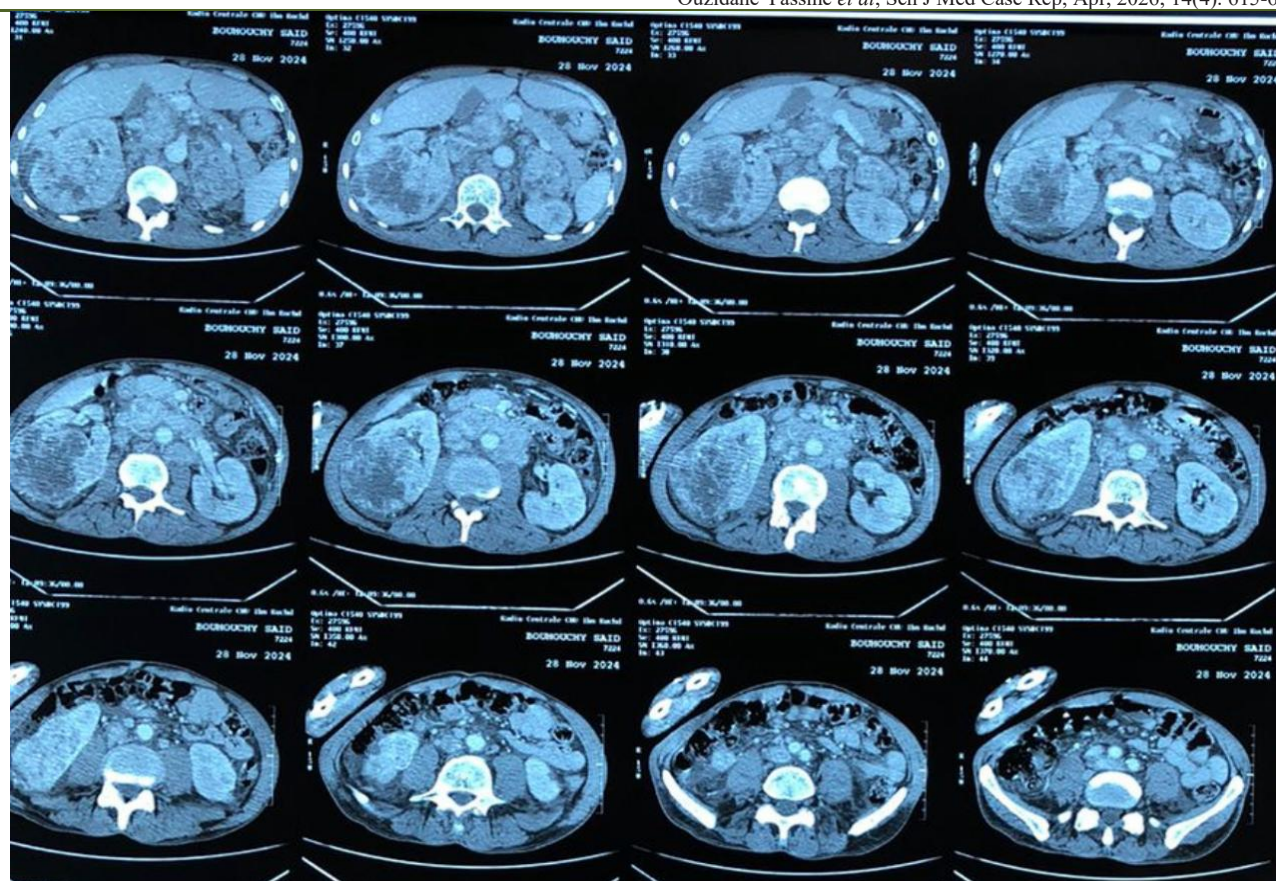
Abdominal and pelvic CT scan showing a locally advanced tumor in the right kidney
